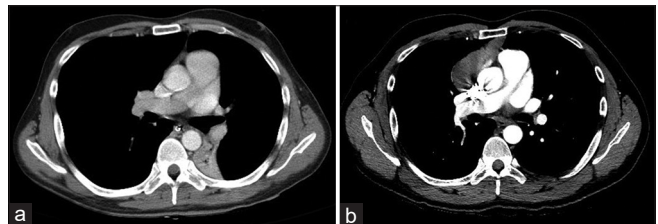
The CT thorax at first admission (a) during the crisis and subsequent CT thorax done after 2 years follow-up (b). The thymoma was not evident on the first scan and was only detected on the second scan
